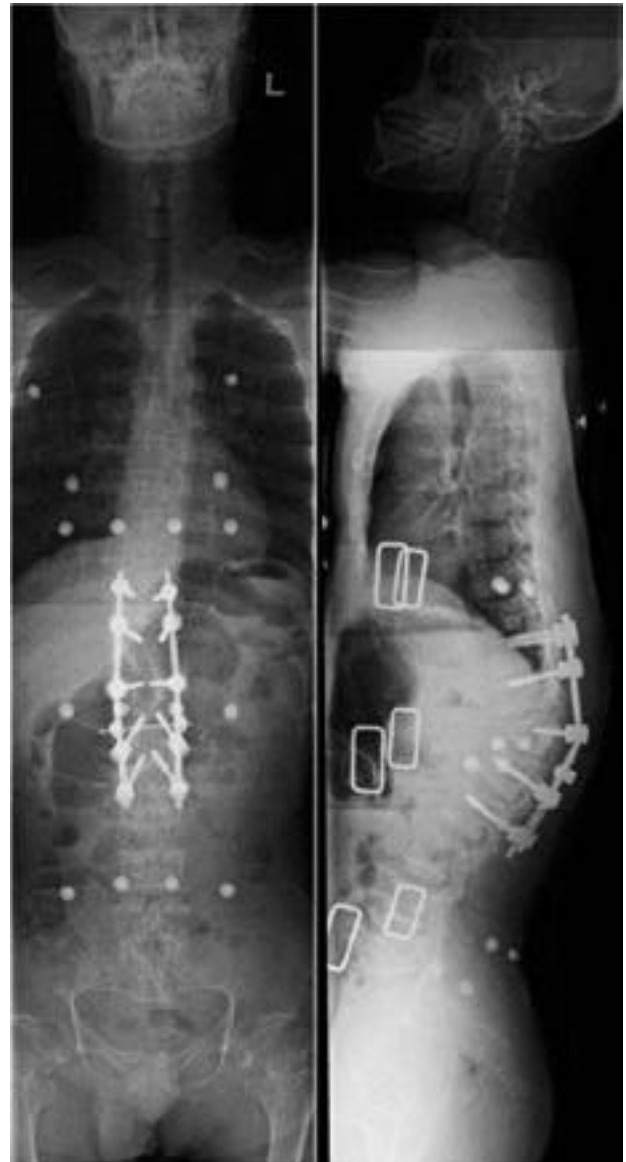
The simple radiography of whole spine anteroposterior and lateral view in postoperative state. The Cobb's angle is decreased to 52 degree at level of thoracolumbar junction. Sagittal vertebral axis(SVA) is corrected to negative 3.6 cm which from posterosuperior corner of S1.
